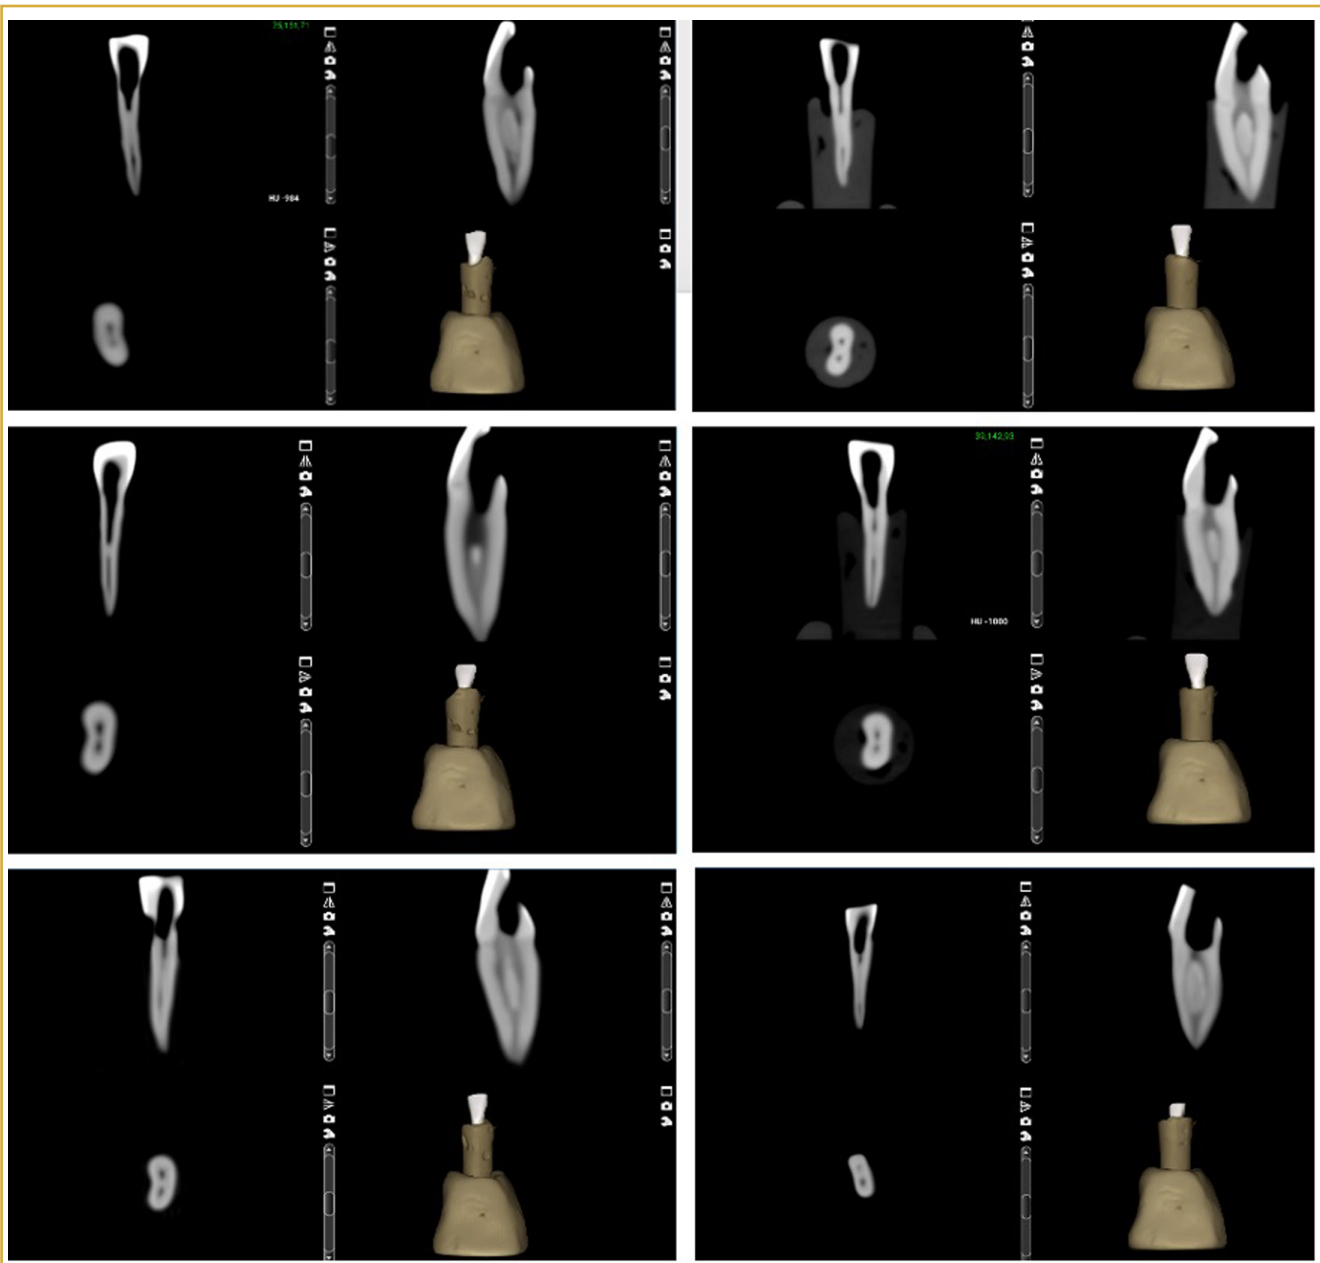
Cone beam computed tomography images of mandibular incisors with 2 canals.
